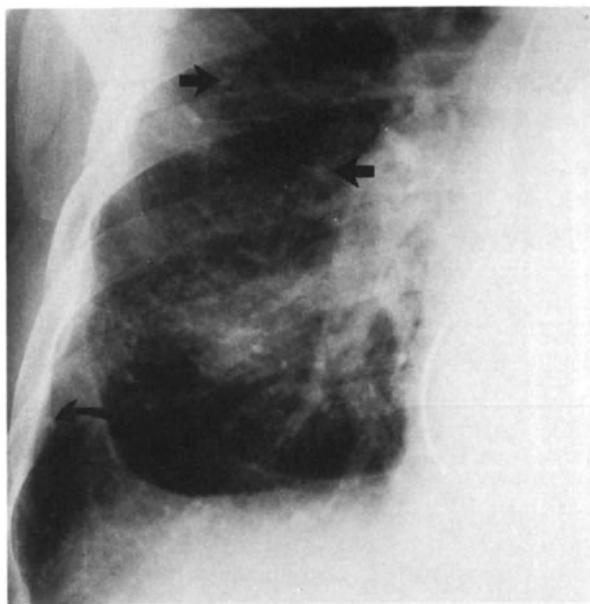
Close up view from chest radiograph showing pulmonary hemosiderosis (straight arrows) and pulmonary ossification (curved arrows) in a patient with severe mitral valve disease.
